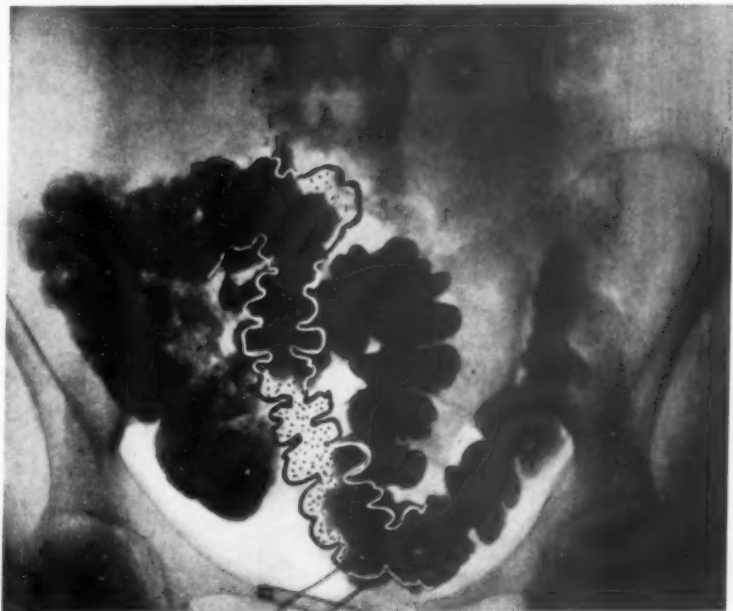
Radiographs taken in the upright position at 6 feet (no distortion) under identical conditions, 5 and 5½ days after barium meal. The drawn contours indicate the position of the colon as traced from the second radiograph (5½ days). "Isomorphic" haustration. Opaque contents have not moved beyond splenic flexure. Serpentine mobility of transverse colon. A girl 21 yrs. old.
